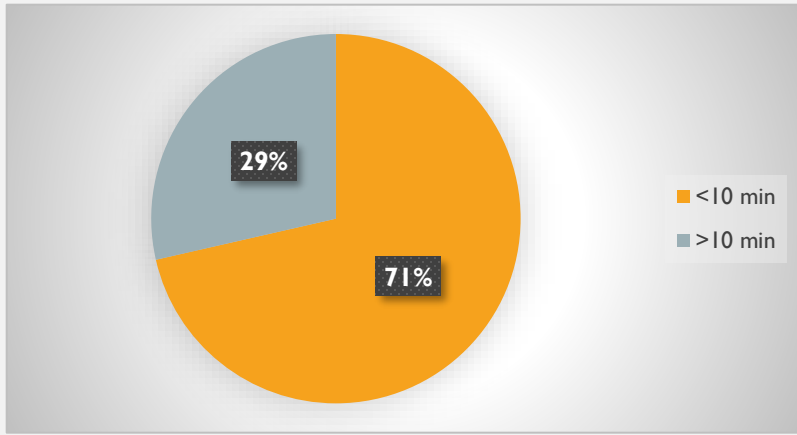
Average Waiting Time of X-ray
